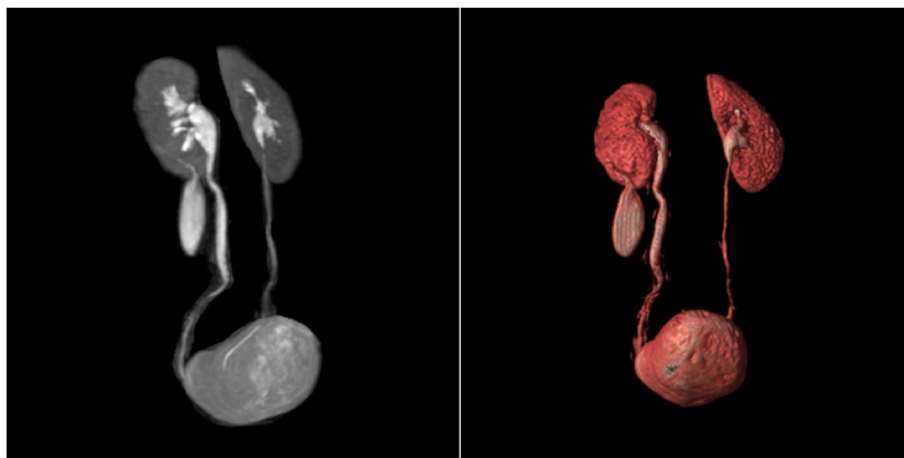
3D reconstruction of a contrast-enhanced MRI displaying a large fusiform extra-renal structure that fills with contrast during the excretory phase of the exam.
